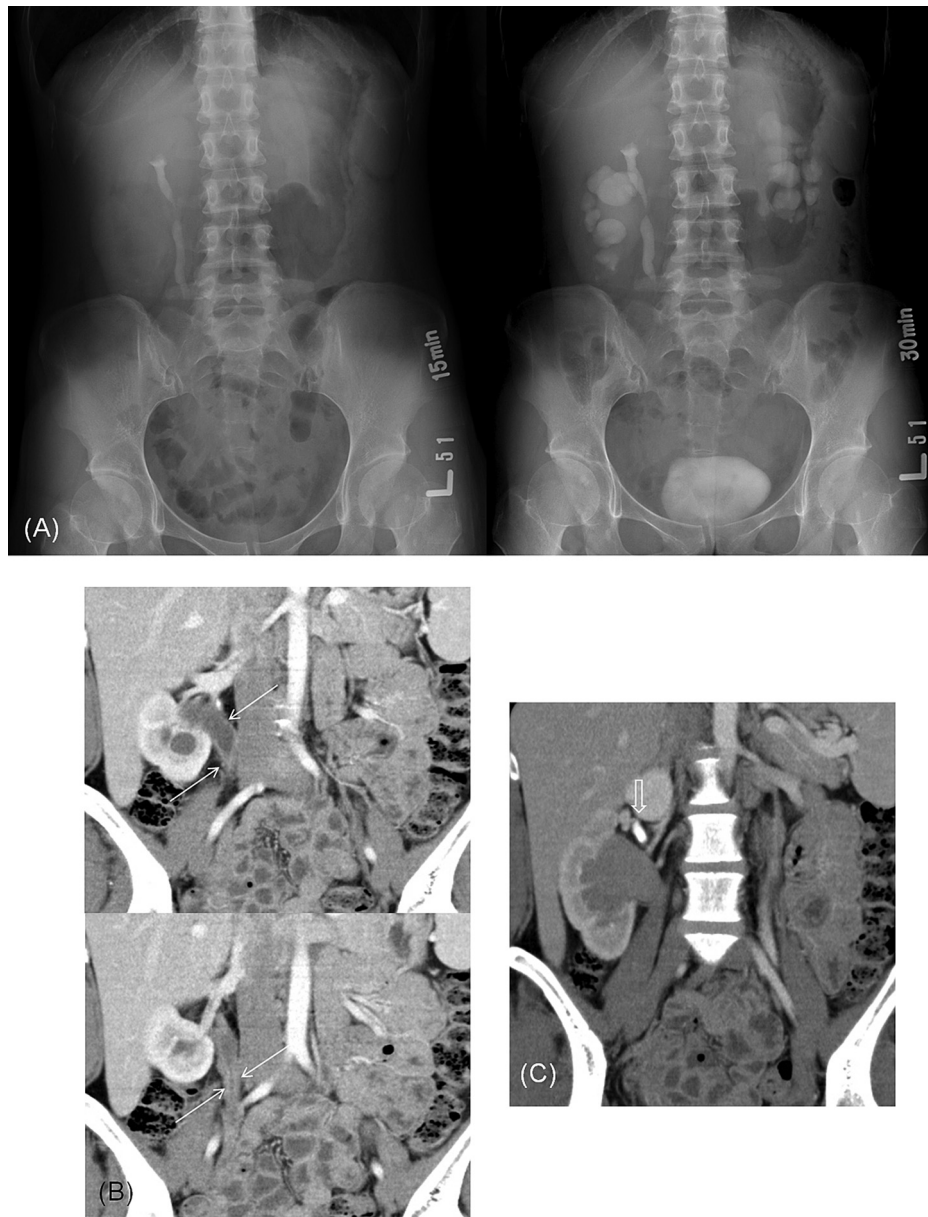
A 26-year-old woman with a 2-year history of ketamine abuse, observed to have hydronephrosis and suspected to have ureteral involvement of KIU. (A) IVU study (left, 15-minute film; right, 30-minute film) reveals duplication of the right kidney. Only the collecting system of the upper moiety is opacified. The lower moiety of the right and left kidneys shows delayed function and hydronephrosis, while the obstruction level and cause could not be decided. (B, C) The coronal reformation images of three-phase CTU exam [(B) nephrographic phase and (C) excretory phase] reveals diffuse thickening of the wall of the lower moiety of the right collecting system (arrows in B) and dilatation, indicating KIU involvement. In excretory phase, the uninvolved upper moiety is opacified (open arrow in C). Note the unsymmetrical renal function of the upper and lower moiety of the right kidney. CTU = computed tomography urography; IVU = intravenous urography; KIU = ketamine-induced uropathy.
